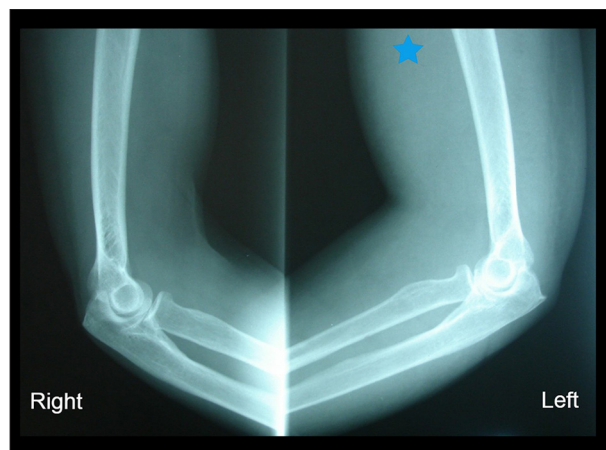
Upper limbs radiograph, lateral view. Significant soft-tissue swelling is present in the left arm, without any emphysema in the surrounding area (asterisks).
